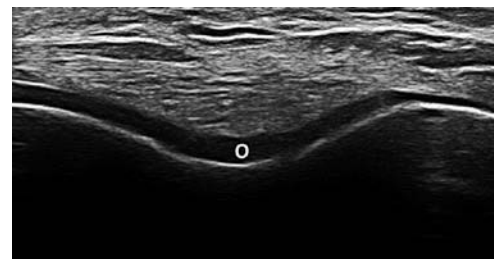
Ultrasound of the knee in a healthy individual. Transverse suprapatellar scan. Normal hyaline cartilage of the femoral condyles (o) is visualized.
